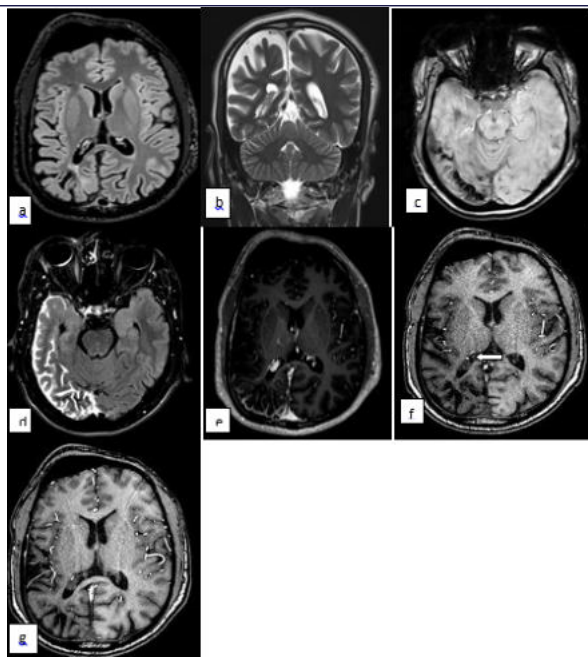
Axial FLAIR and coronal T2WI of MRI brain plain (a & b) showing moderate atrophy of the right cerebral hemisphere involving more of parietal and occipital lobes with enlarged right choroid plexus and enlargement of ipsilateral frontal sinus.
